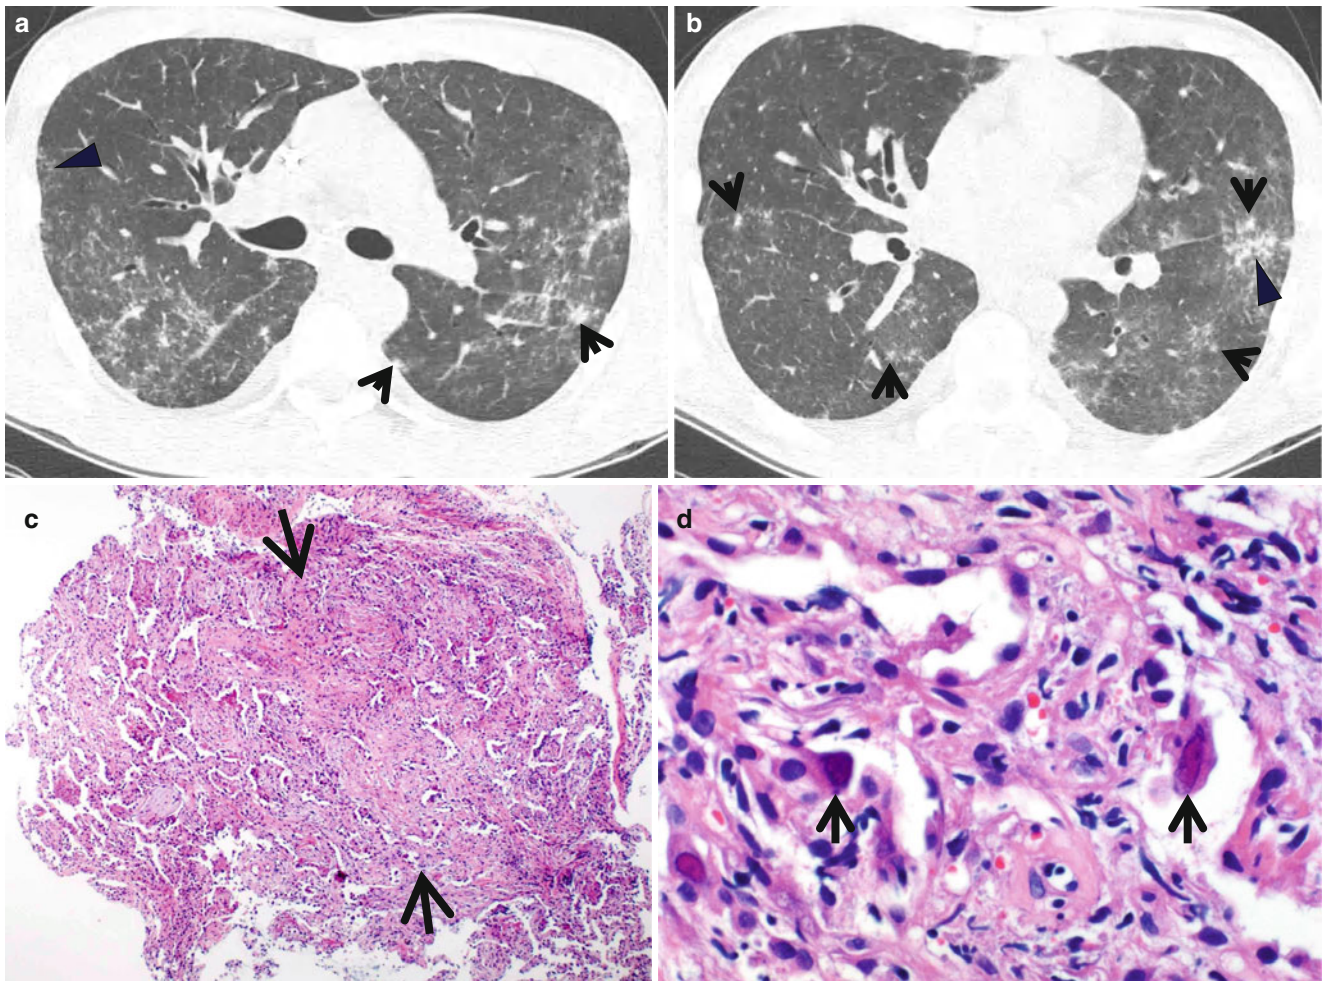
Cytomegalovirus pneumonia in a 28-year-old man with acute myeloid leukemia. (a, b) Lung window images of thin-section (1.0-mm section thickness) CT scans obtained at levels of main bronchi (a) and basal trunk (b), respectively, show patchy areas of ground-glass opacity in both lungs associated with branching small nodular structures (tree-in-bud sign, arrowheads) and somewhat larger nodules
